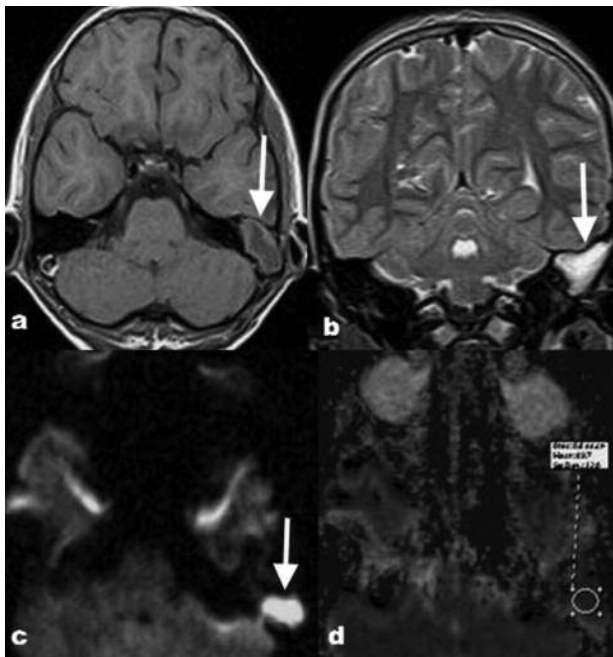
A case of left middle ear cholesteatoma. MRI shows hypointense on T1-weighted image (arrow, a) and hyperintense on T2 (arrow, b). DWI shows hyperintensity in this same area (arrow, c). ADC value was measurement $0,69 \times 10^{-3} \text{ mm}^2/\text{sec}$ (d).
